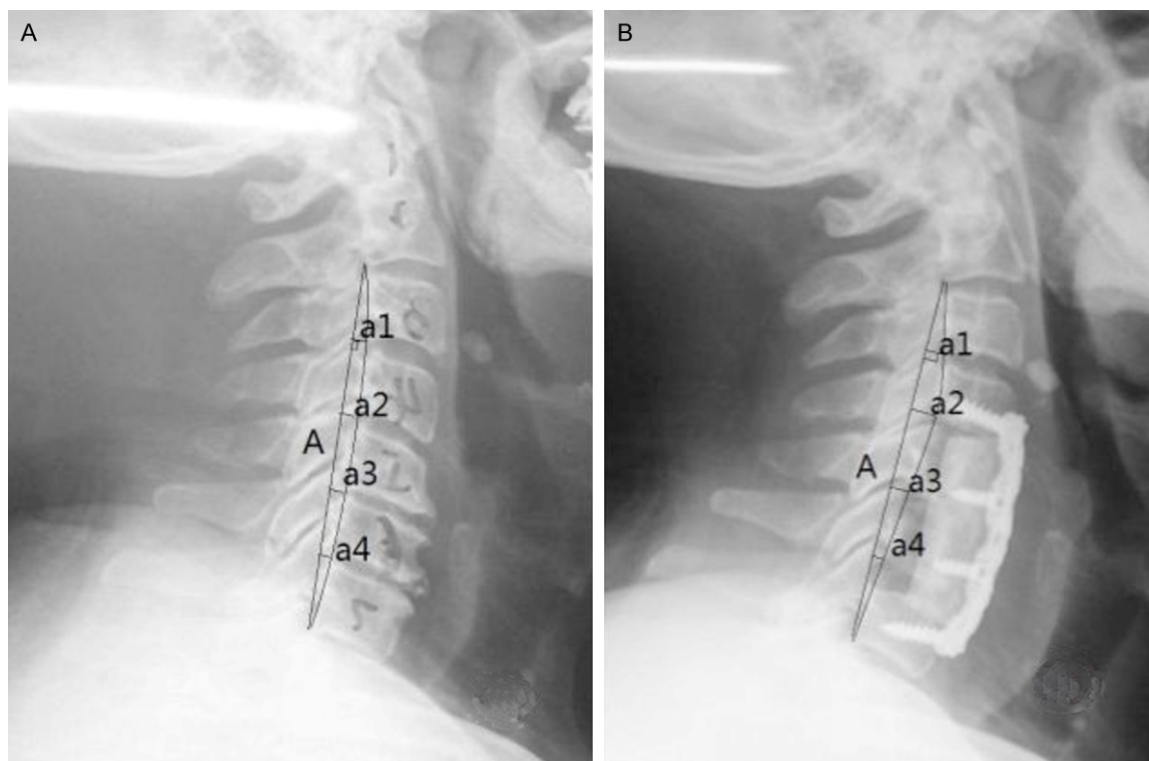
CCI measurement: a lateral radiograph was obtained, and a line connecting the posterior lower corner of C2 and C7 was drawn. The length of this line was A; the distance between the posterior lower corner of different vertebral bodies (C3 and C6) and the former line was a1, a2, a3 and a4, respectively; CCI was calculated: $CCI = (a1 + a2 + a3 + a4)/A \times 100\%$. A. Preoperative CCI; B. Postoperative CCI.
